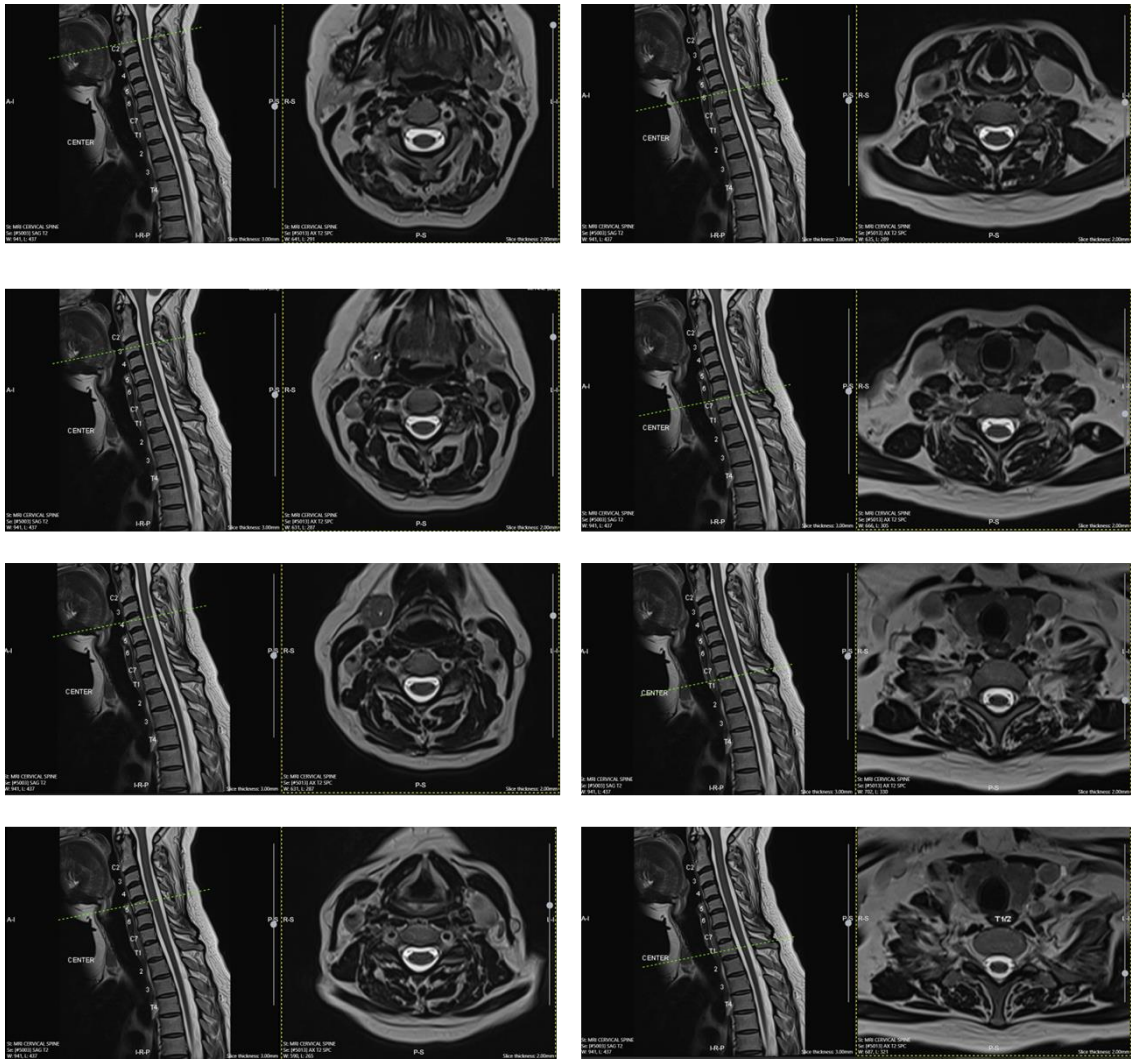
Sagittal and axial cervical MRI scans.
